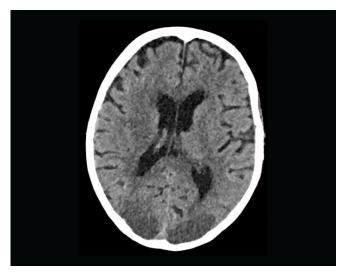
CT Head showing bilateral, symmetrical abnormal cortical and subcortical ischaemic change is seen in both occipital lobes. There is also mild local mass effect with gyral swelling.
